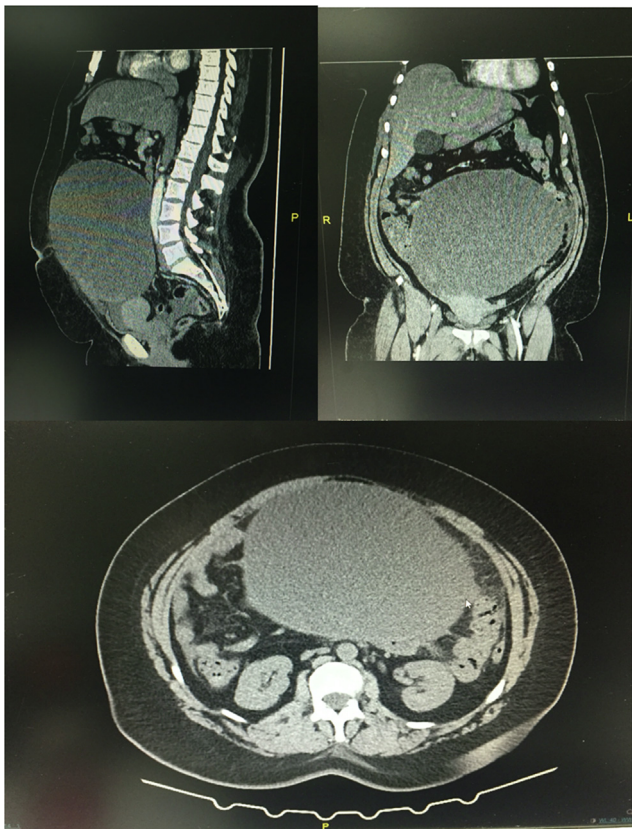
Preoperative CT scan image.
